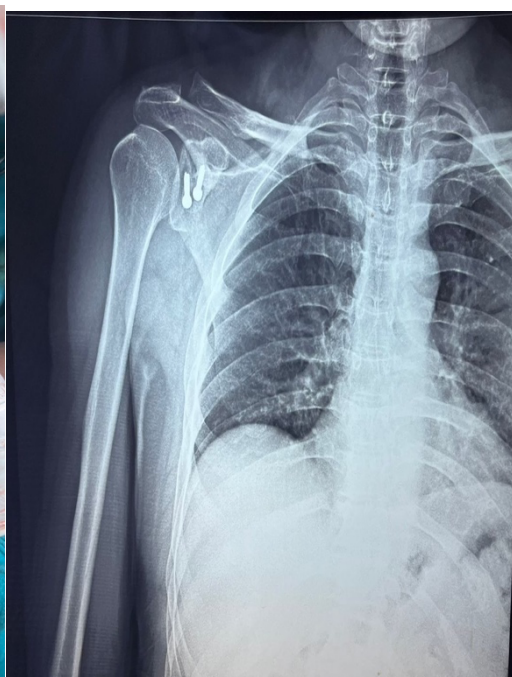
Radiograph showing immediate post operative
